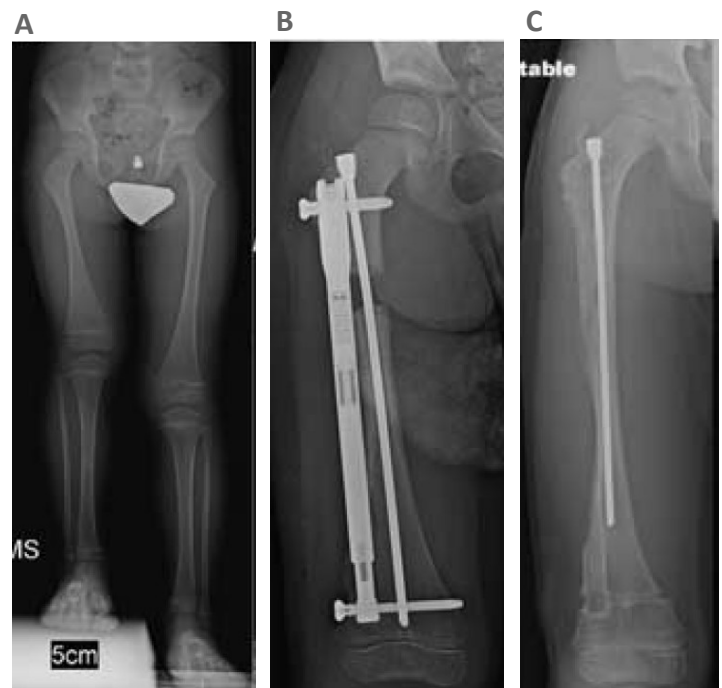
FIGURE A, AP standing x-ray of a patient with right congenital femoral deficiency. The diameter of the femoral diaphysis is too narrow to accommodate an intramedullary lengthening nail, although the length of the bone is adequate. The hip is well covered and the knee was stable on clinical examination. B, Gradual (0.75 mm/d) lengthening with an extramedullary trochanteric PRECICE nail over the SLIM rod. C, Postoperative anteroposterior and lateral x-ray at the time of removal of an extramedullary femoral lengthening nail. Note the distal metaphyseal channel where the nail was docked into the bone.
